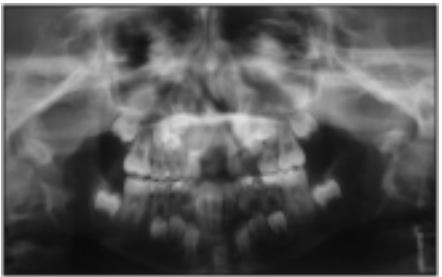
Figure IV; Postoperative radiograph of the patient.
